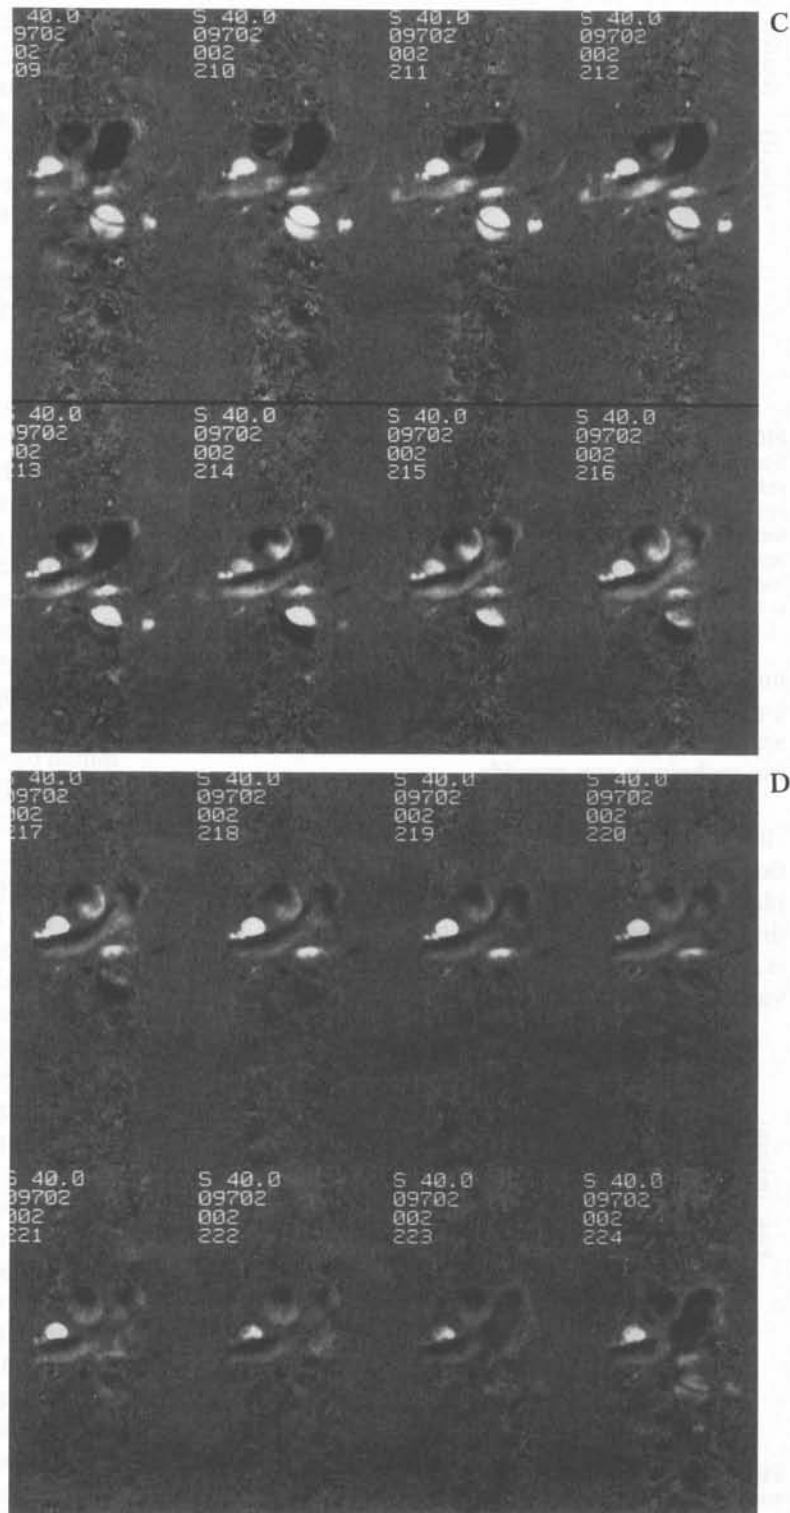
C and D: The corresponding superior-inferior encoded phase contrast cine MRI images. There is strong caudal flow (bright) in both lumens of the descending aorta in the beginning of the cycle, with prominent reversal of flow (bright to dark) in the false lumen late in the cycle.
